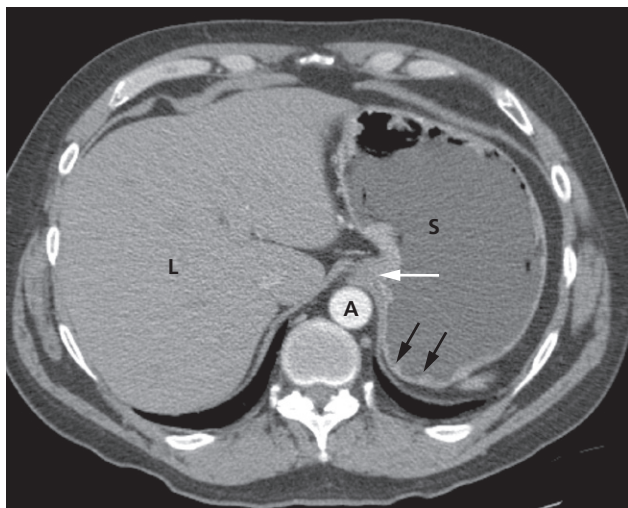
CT of a normal stomach. The stomach has been distended by oral water contrast and the use of an intravenous smooth muscle relaxant. Some normal rugal folds are still visible (black arrows). Note the gastro-oesophageal junction (white arrow). A, aorta L, liver; S, stomach.
